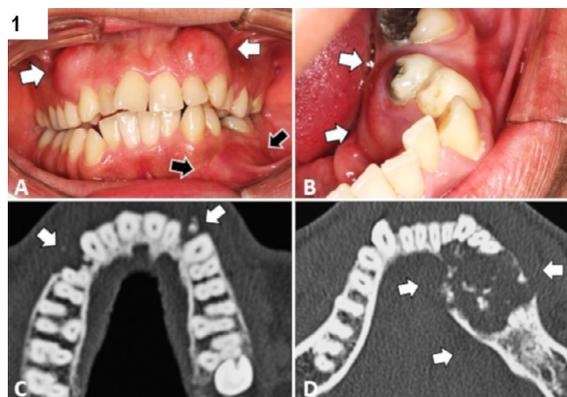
Clinical aspect of a patient with multiple calcifying epithelial odontogenic tumor (CEOT). (A) Bilateral gingival swelling in the anterior maxilla (white arrows) and expansion of the buccal plate in the mandible (black arrows). (B) Bicortical expansion of the mandible with tooth displacement from the left lateral incisor to the first molar (white arrows). Cone beam computed axial tomography images of the case. (C) Hypodense lesion with hyperdense material and disruption of the vestibular cortical bone in both maxillary lesions (arrows). (D) Similar aspect with bicortical bone expansion in the mandible tumor (arrows).
